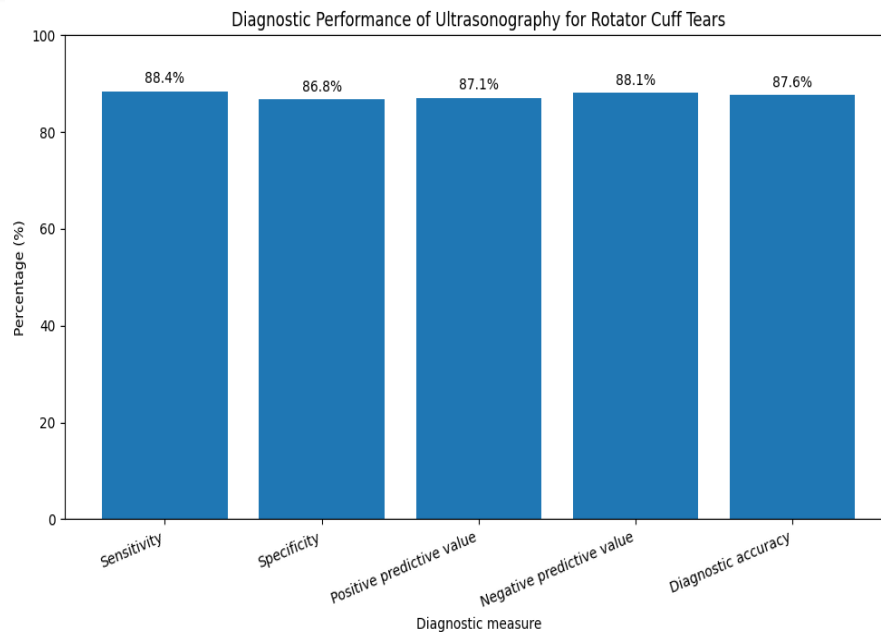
Diagnostic performance of ultrasonography for detecting rotator cuff tears using magnetic resonance imaging as the reference standard. Ultrasonography showed a sensitivity of 88.4%, specificity of 86.8%, positive predictive value of 87.1%, negative predictive value of 88.1%, and overall diagnostic accuracy of 87.6%.
